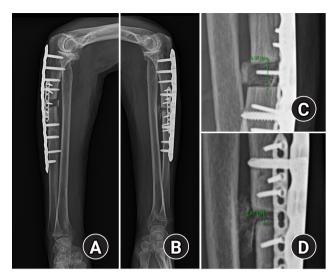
Postoperative lateral plain X-rays of the right (A) and left (B) forearms. The gaps were measured as 9.9 mm on the right (C) and 3.9 mm on the left (D).
